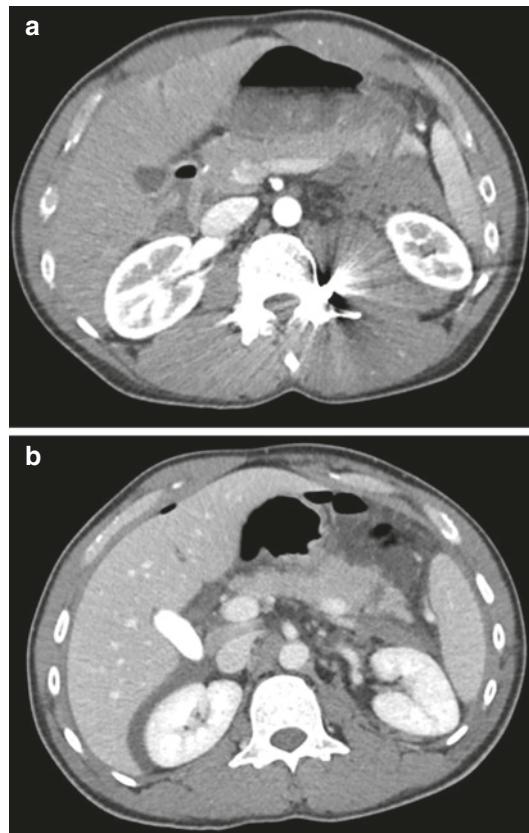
A 36-year-old man was admitted to the emergency department following a gunshot injury. IV contrast-enhanced CT axial image shows a bullet within the left iliopsoas muscle and a large retroperitoneal hematoma. Note also multiple streak artifacts (a) extending up to the abdominal wall, passing through the pancreatic tail. Follow-up CT after bullet removal clearly demonstrates a deep laceration in the pancreatic tail (b). Comment: streak artifacts may mask significant injuries. Repeat CT after removal of radiopaque foreign bodies after trauma, if possible, may be advisable for definitive assessment
